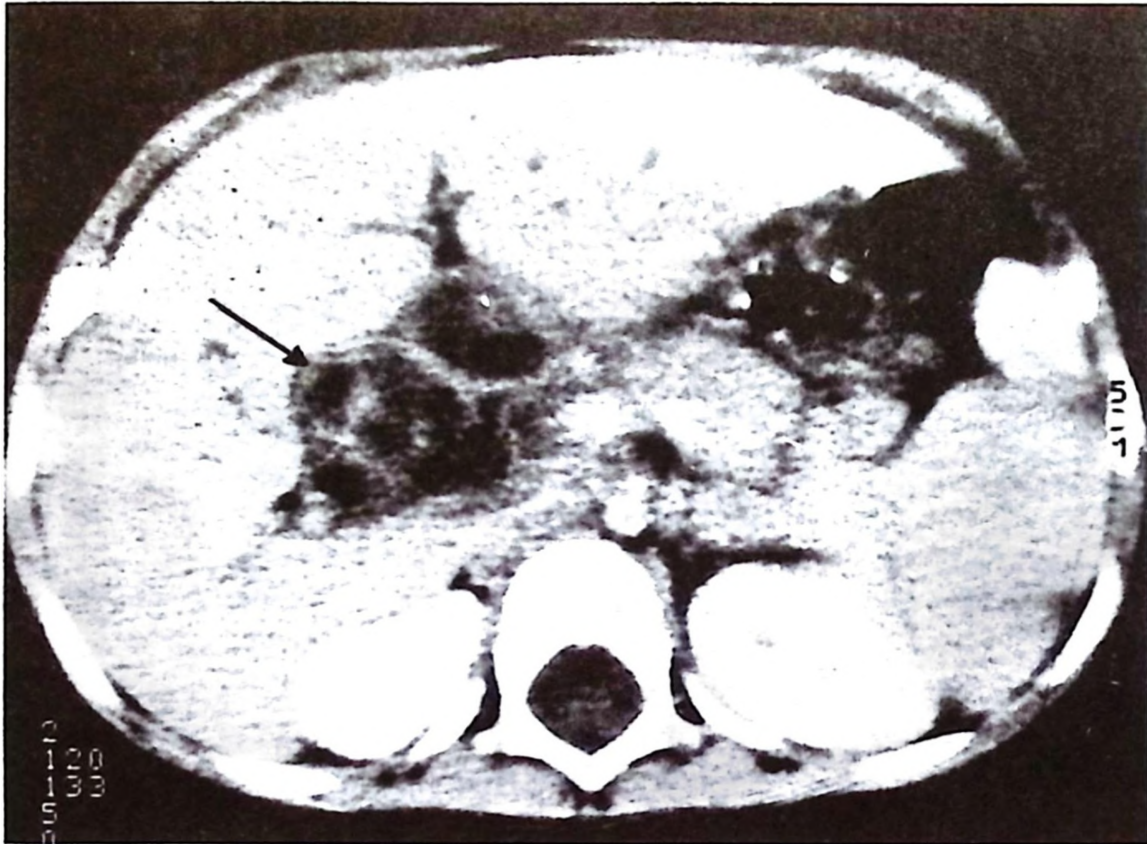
Computed tomography CT scan of the abdomen at the level of T12-L1 levels the mass between the porta hepatis and the head of the pancreas.
